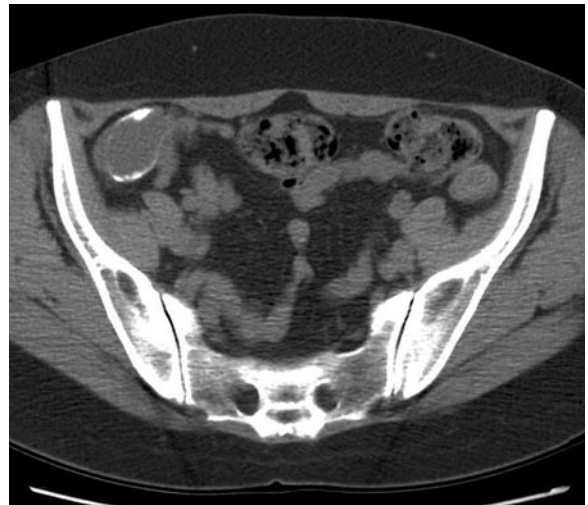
Mural calcification of incidental appendiceal mucocele. Noncontrast CT image shows a cystic lesion in the right lower quadrant in the expected location of the appendix with coarse curvilinear mural calcification, which was confirmed to be a benign mucinous adenoma of the appendix
